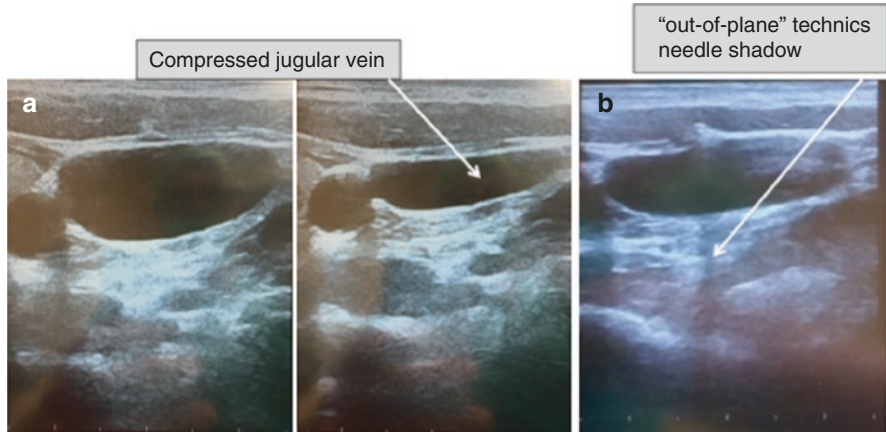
B-Mode ultrasound of internal jugular vein: (a) compression maneuver; (b) needle insertion through transverse plane (“out-of-plane”)
